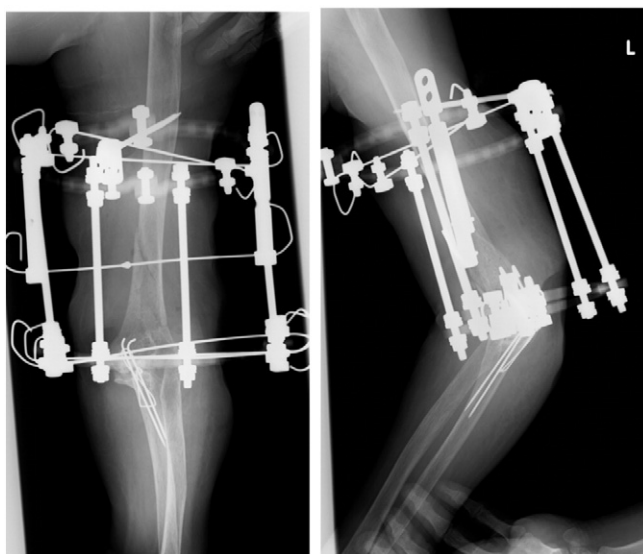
Postoperative X-rays of the left elbow obtained immediately after surgery. Closed indirect reduction was performed with an Ilizarov fixator.
